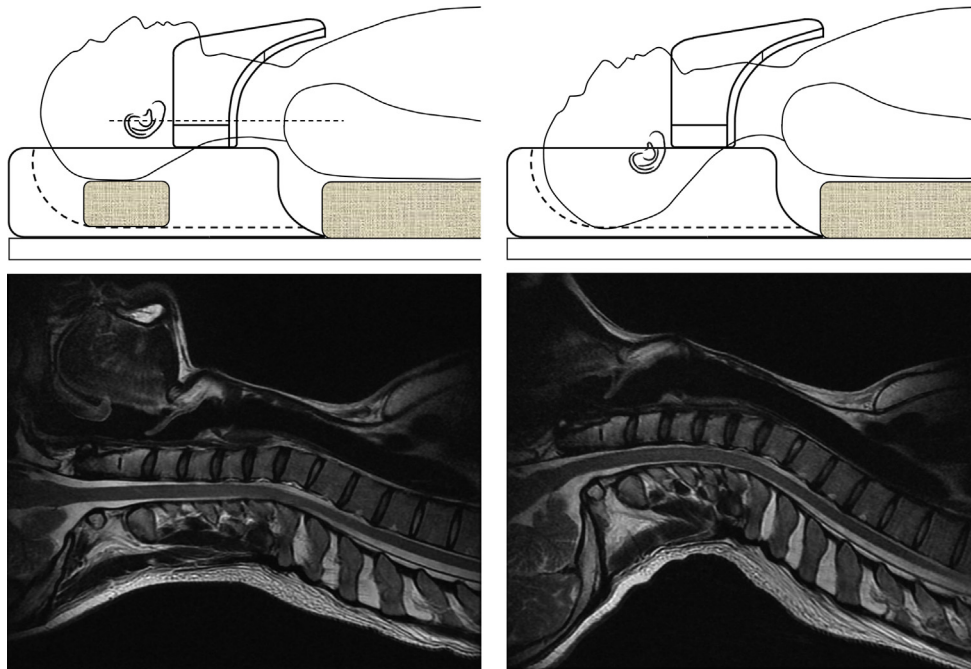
Postures for acquiring T2-weighted sagittal images of neutral (left) and extended (right) cervical spines in supine position.
